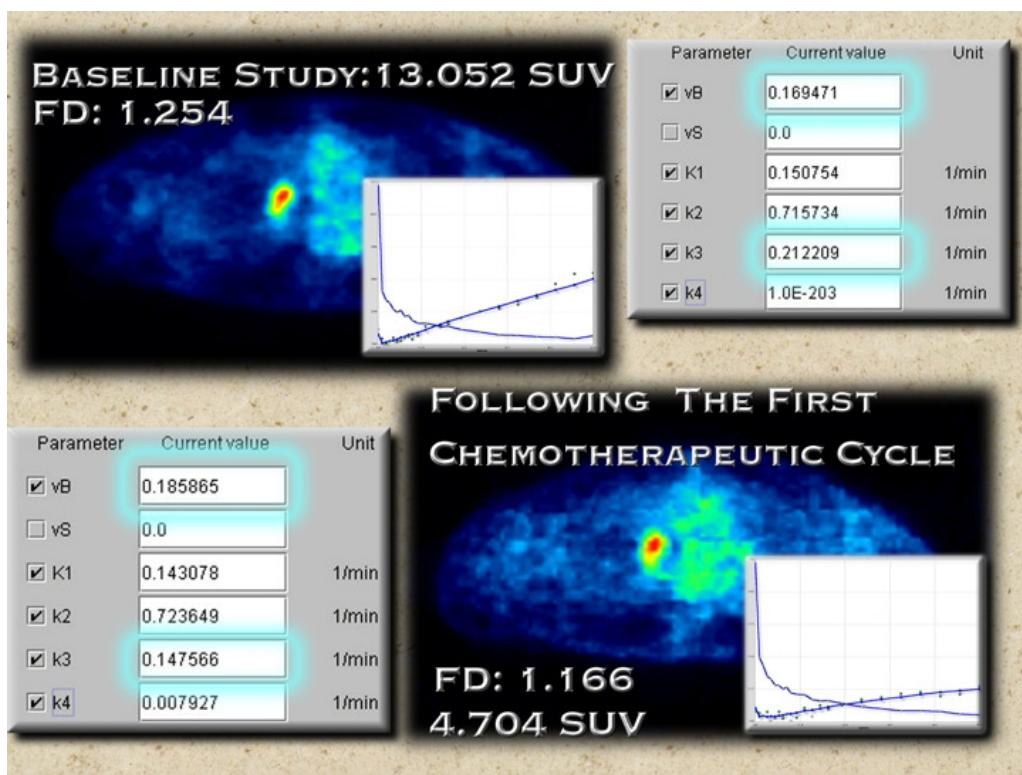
FDG study prior and after one FOLFOX cycle in a patient with a lung metastasis of colorectal cancer located in the right hilar region. The kinetic data demonstrate a decrease in the phosphorylation rate k3 and a slight increase in the vessel density. This patient responded to FOLFOX chemotherapy and showed an overall survival of 801 days.
